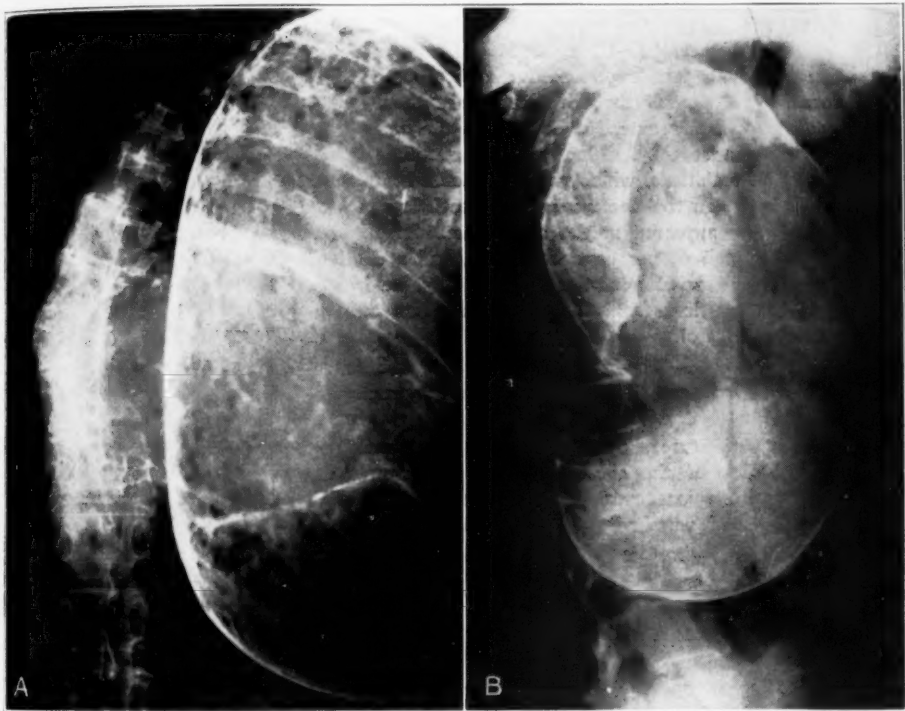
(case 5).—*A*, anteroposterior roentgenogram of the thorax and spine, showing a large tumor of the chest with erosion and angulation of the vertebrae. This tumor is of tuberculous origin and is not associated with the hour-glass tumor at the level of angulation shown in the film. *B*, lateral view of the tumor shown in *A*.
